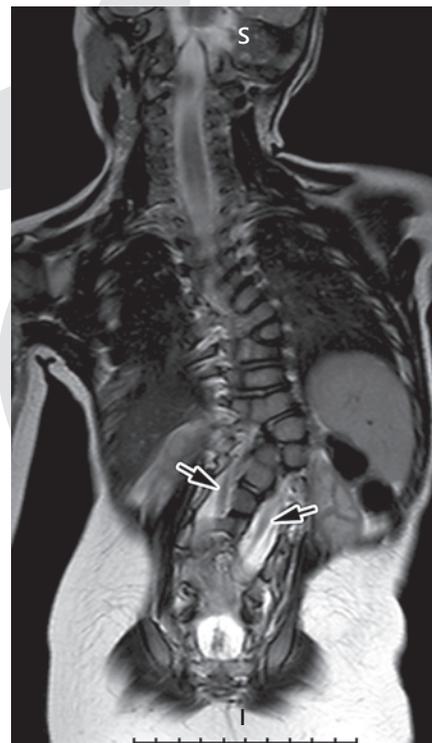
Split spinal cord (arrows) in the lumbar region on a T2-weighted coronal MR image.
